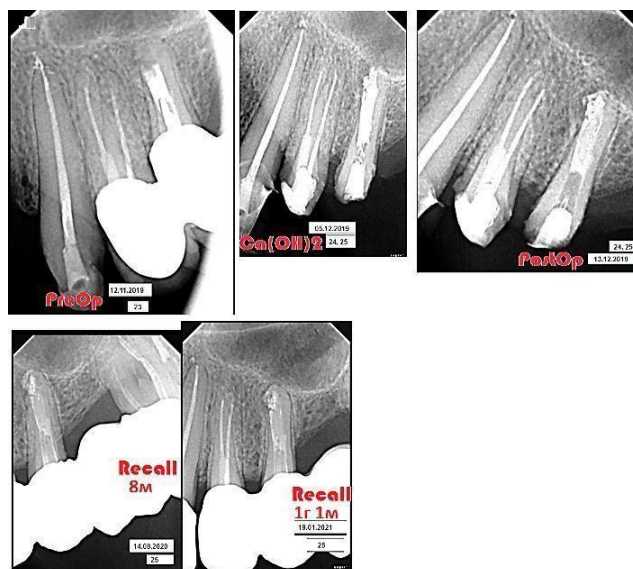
Radiographs of tooth 25: 3 years and 2 months after completion of treatment; during retreatment; 8 months after completion of treatment; 13 months after completion of treatment.
